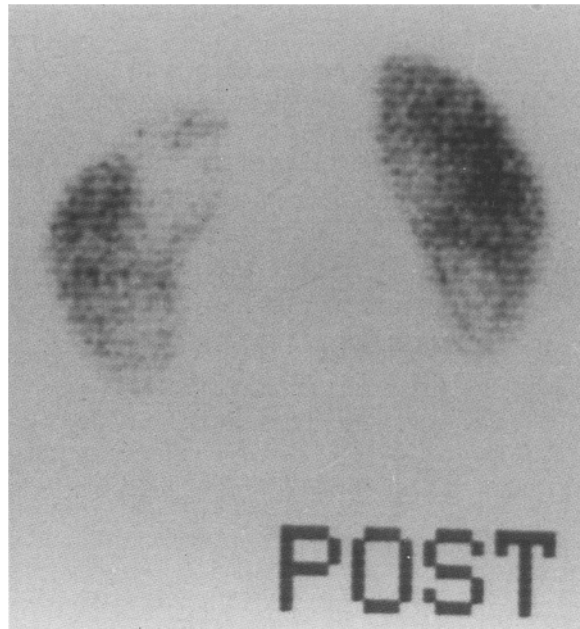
^{99m}Tc -DMSA scintigraphy (post view) in a 5-year-old child. First urinary tract infection. The normal renal cavities are well delineated as hypolucent areas, separated by strips of hyperactivity, converging from the periphery of the kidney to the hilus. A large hypoactive area is seen at the upper pole of the left kidney, without deformation of the renal outlines, thus suggesting, in the absence of structural abnormalities on ultrasound, the diagnosis of left acute pyelonephritis
